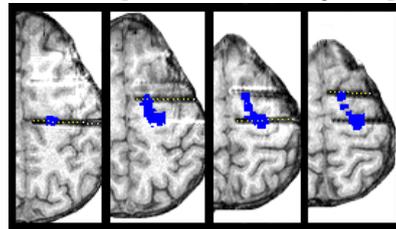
A patient post-SEEG implantation MRI axial slices overlaid with the activated SEEG electrodes (yellow dots) and the detection map (blue).
